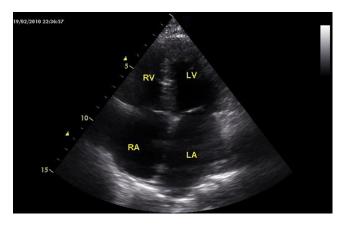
Echocardiography (apical 4-chamber view) shows enlarged right atrium (RA) and left atrium (LA), but normal-sized and contracting left ventricle (LV) and right ventricle (RV).
